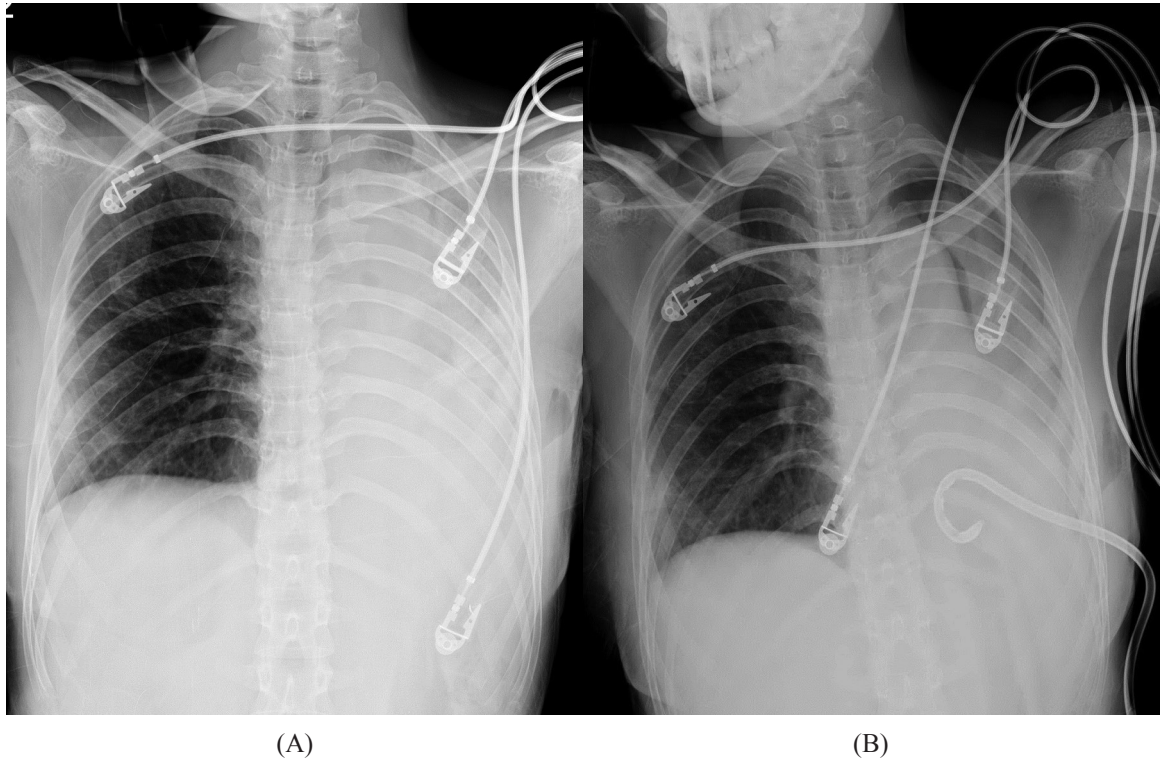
A. Chest x-ray taken in the morning on PTD 32 due to breathing difficulty with desaturation. B. Chest x-ray taken after pigtail insertion on the same day.
